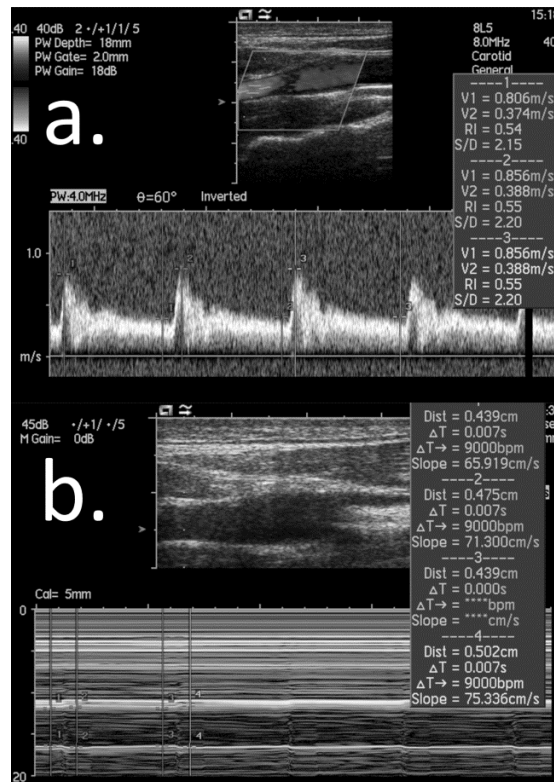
Flow velocity (a) and vessel diameter in M-mode ultrasound (b) measured at the right ICA.
